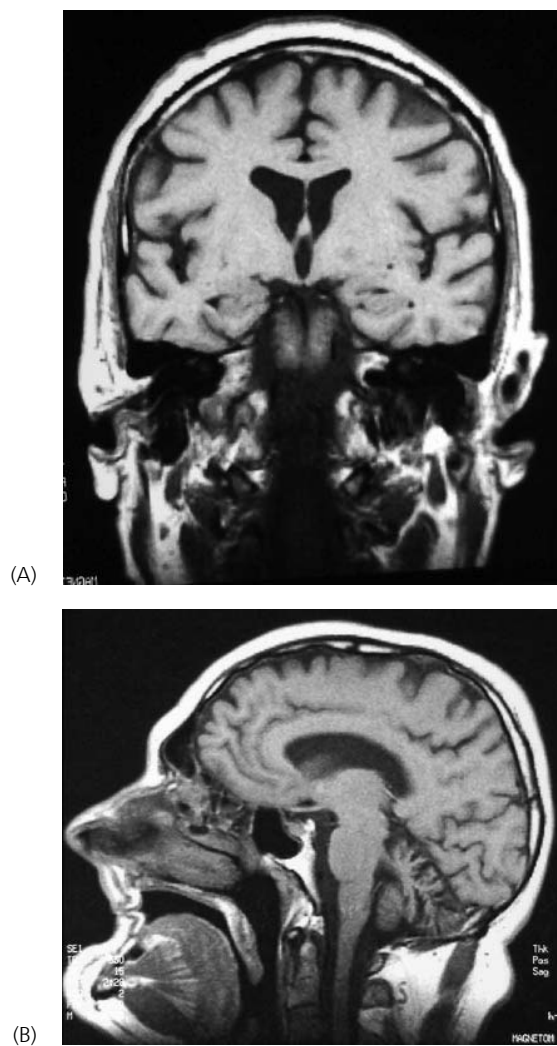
Coronal (A) and sagittal (B) sections of the brain MRI of a 54-year-old painter revealed in  $T_1$ -weighted images central and cortical brain atrophy in frontal, parietal, and occipital brain areas and in the cerebellum and vermis. Atrophy sum score was 6. The patient had hypertension and hypercholesterolemia, he was a smoker, and his average alcohol consumption was 480 g/month. He had been exposed mainly to White spirit and xylene for 40 years (OELY 10).
